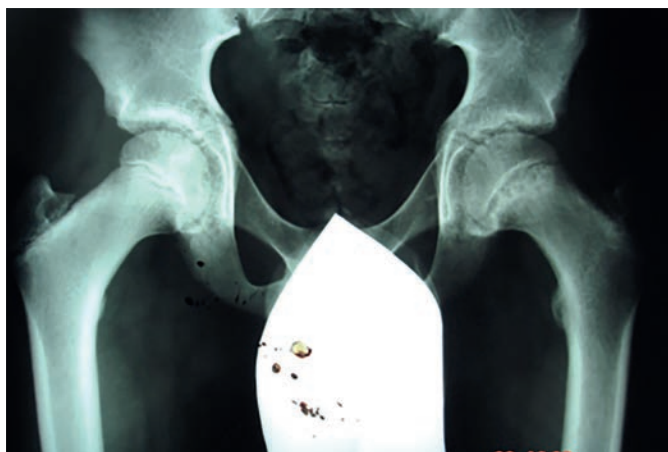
Direct radiograph of the hip joints of patient B., 15 years old with SCFE, 1st displacement degree.
